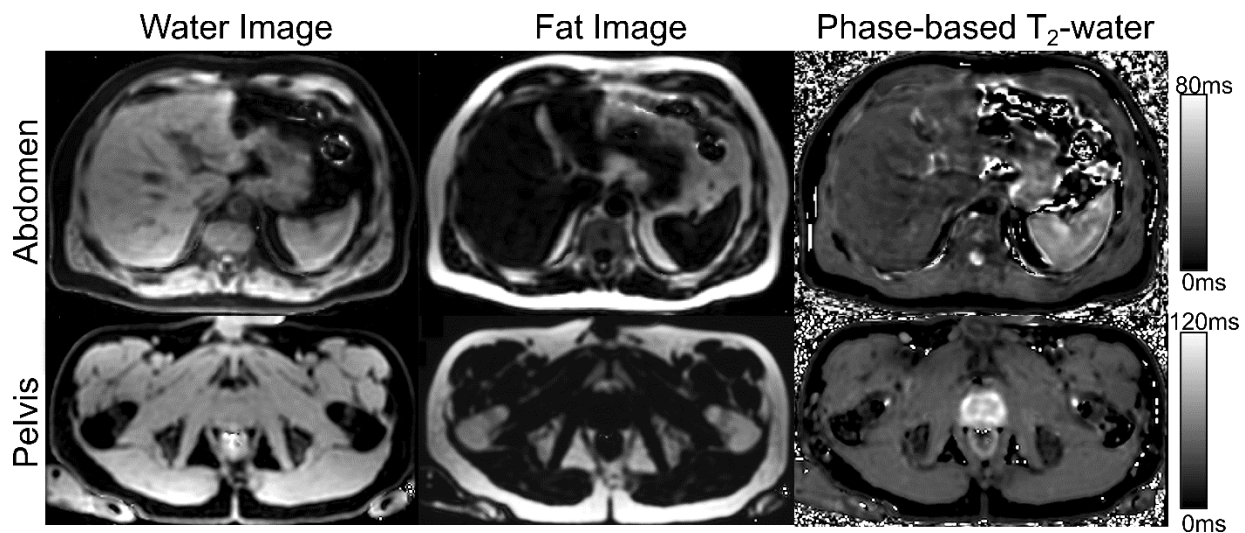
The proposed phase-based 3D T_2 mapping combined with CSE-MRI water-fat separation is feasible over the entire abdomen or the pelvis within a single breath-hold. Water and fat images were calculated from multi-echo gradient echo images with varied RF phase increments. A phase-based T_2 map for water signal was also generated from the water phase of different RF phase increments. Simultaneous R_2^* and B_0 field maps were also generated, but not included for brevity.
